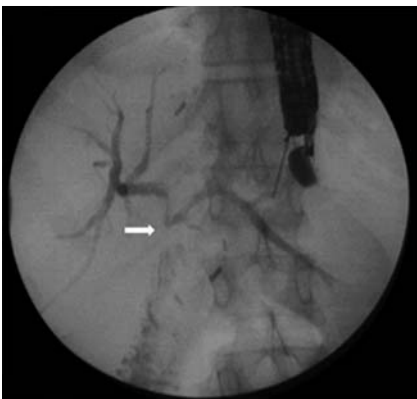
Image taken during an endoscopic ultrasound (EUS)-guided cholangiogram showing stenosis of the hepaticojejunostomy (arrow).
